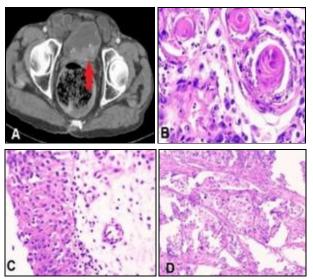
COMPUTED TOMOGRAPHY IMAGES OF 30 YEAR MALE'S BLADDER CANCER
